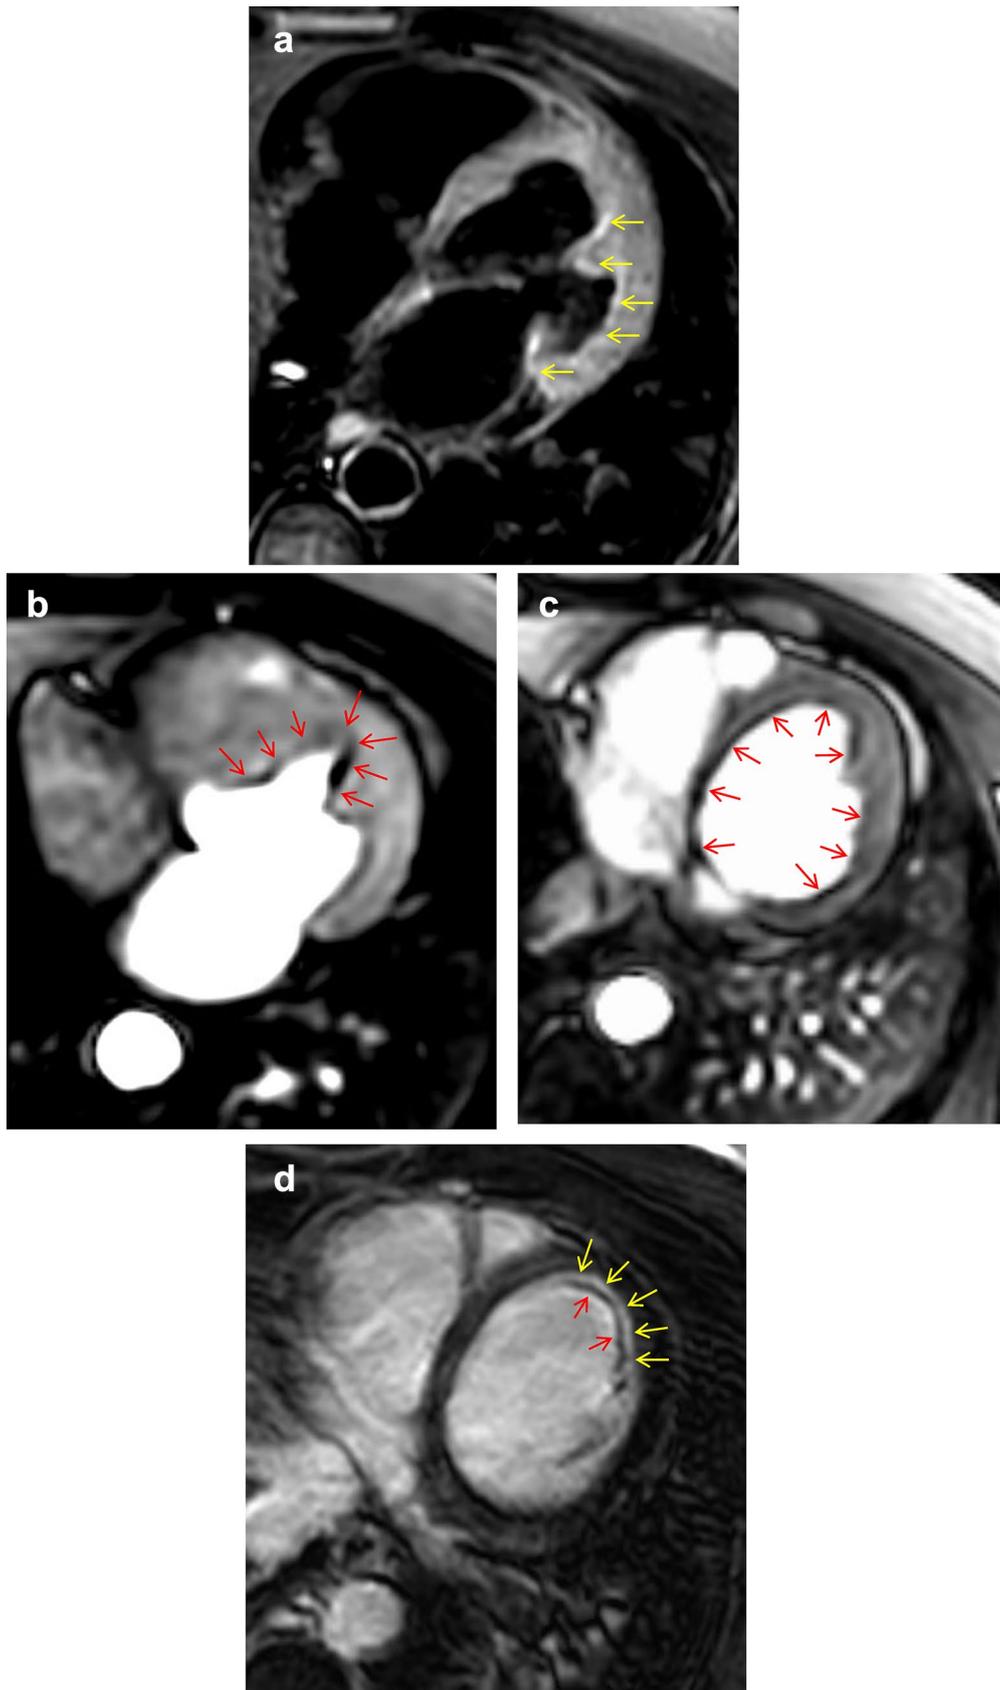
MRI images (November 2016). a A T2-weighted short-tau inversion-recovery (STIR) known as „triple inversion“ spin echo-sequence depicted diffuse myocardial edema (arrows)—preferable in the lateral, subendomyocardial regions. b, c Myocardial perfusion analysis using T1-weighted fast field echo imaging sequences. Subendocardial non-perfused thrombotic layers were documented (red arrows). d A significant subendocardial layer (yellow arrows) of LGE could be visualized in the midapical left ventricular regions with dark superficial thrombus formation (red arrows).
